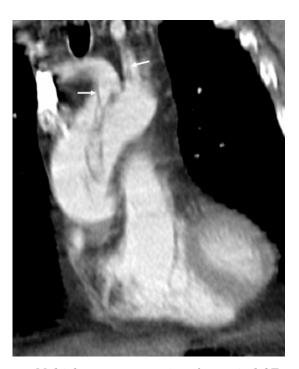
Multiplanar reconstructions from spiral CT: multiple dissection membranes within the aortic arch are demonstrated with involvement of the supra-aortic branches (arrows).
